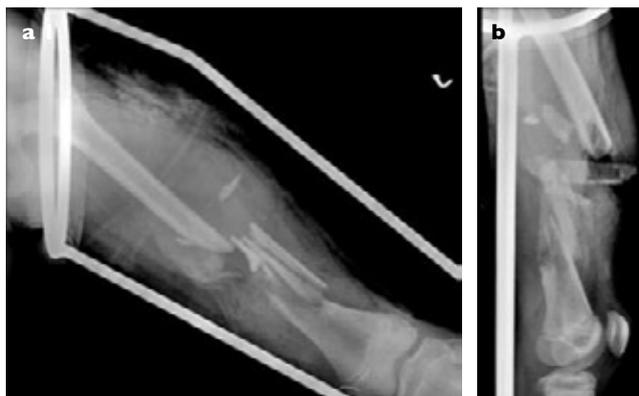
Preoperative (a) anteroposterior and (b) lateral radiographs show a severely comminuted fracture of the shaft of the femur with bone loss.
